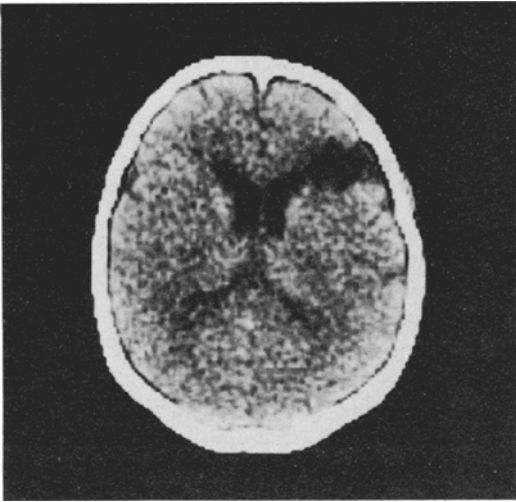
CT-scan of the right frontal hypodense area.
